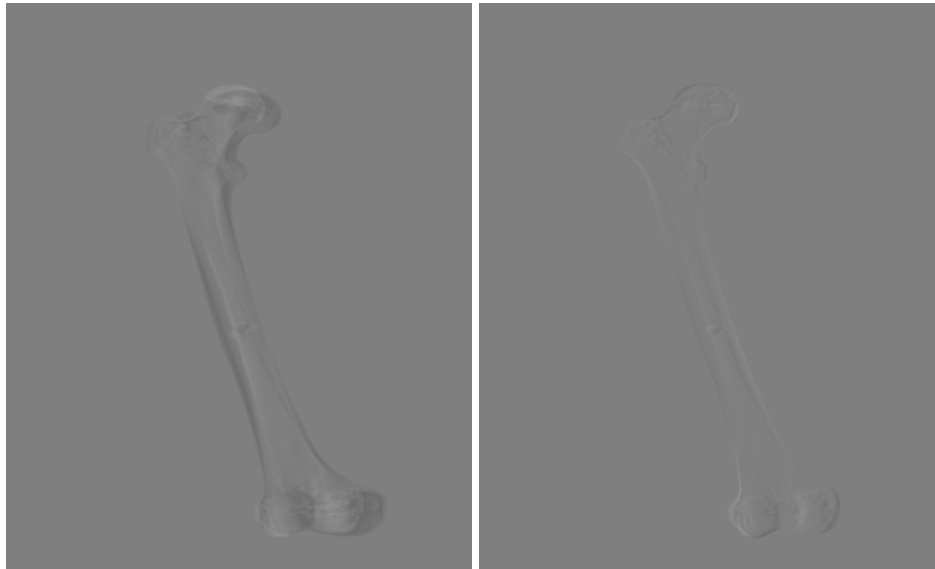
When the initial configuration of the deformable model is too dissimilar from the target X-ray image, the parameter search strategy can get caught in local minima, resulting in an insufficiently accurate patient-specific reconstruction.
